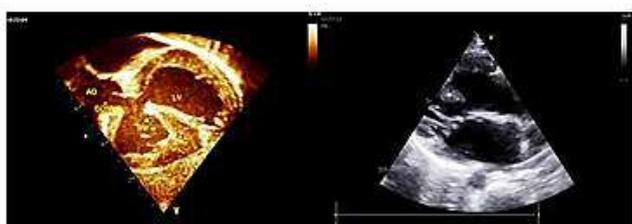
Parasternal long axis view aorto mitral discontinuity 90% overriding large VSD.
